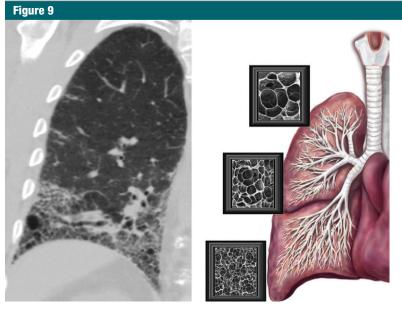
UIP-IPF in 77-year-old man. Lower-lobe peripheral distribution of typical reticulation and cyst formation is more readily evident on coronal reconstruction of axial CT data (left) than on source data. Right: Distribution of lower-lobe cysts in UIP-IPF follows normal distribution of alveolar size when patient is upright. Small basal and dependent alveoli are more likely to collapse than large upper-lobe alveoli and remain closed after diffuse lung injury.
